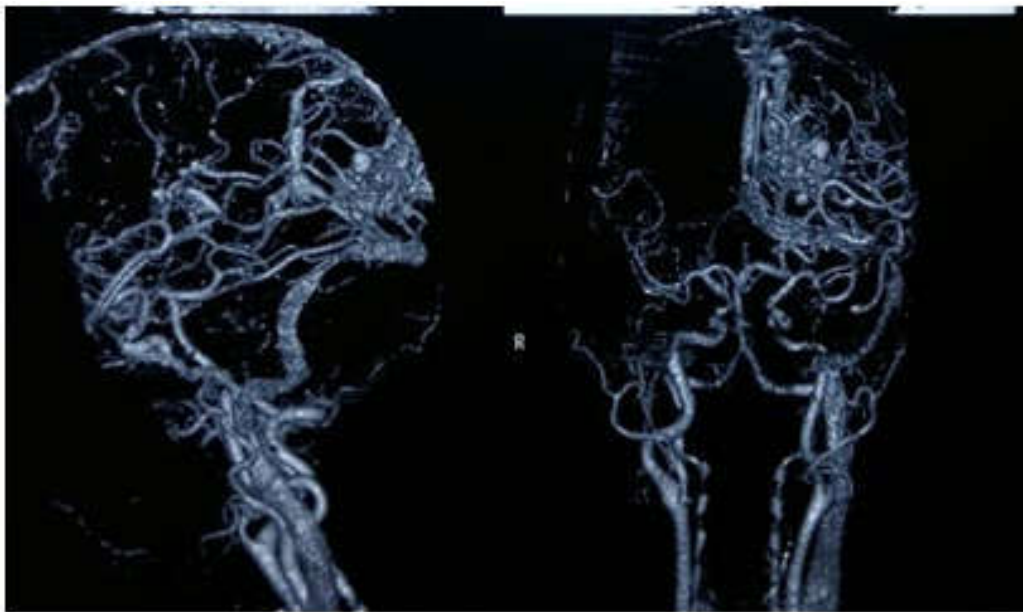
Case Report 1 (a) T2 MRI showing arteriovenous malformation in left occipital lobe
